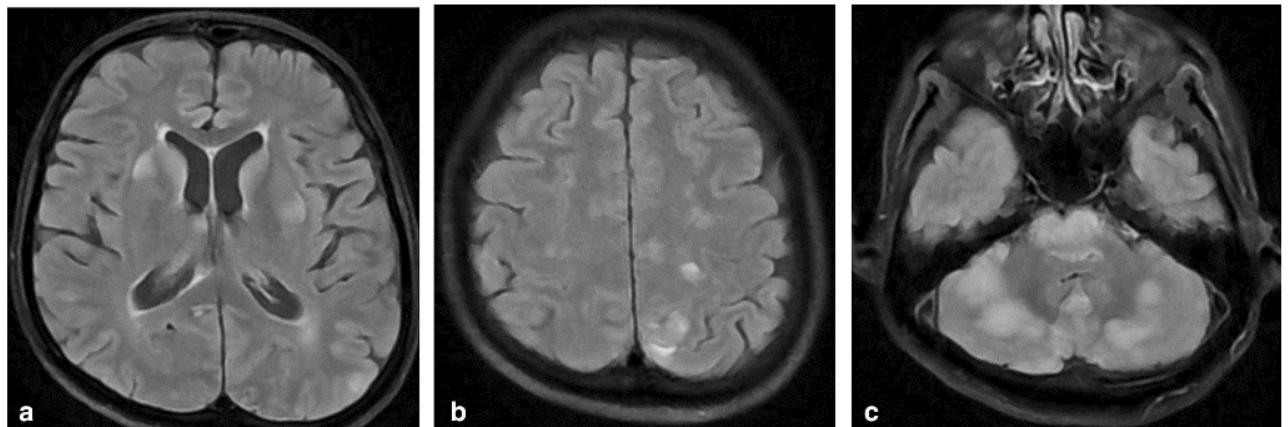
Brain MRI of a 48-year-old male with MOGAD-related encephalitis who presented with generalized tonic-clonic seizures. The lesions exhibit typical MOGAD characteristics—bilateral, asymmetrical, T2 hyperintense, and poorly demarcated with a "fluffy" appearance.
